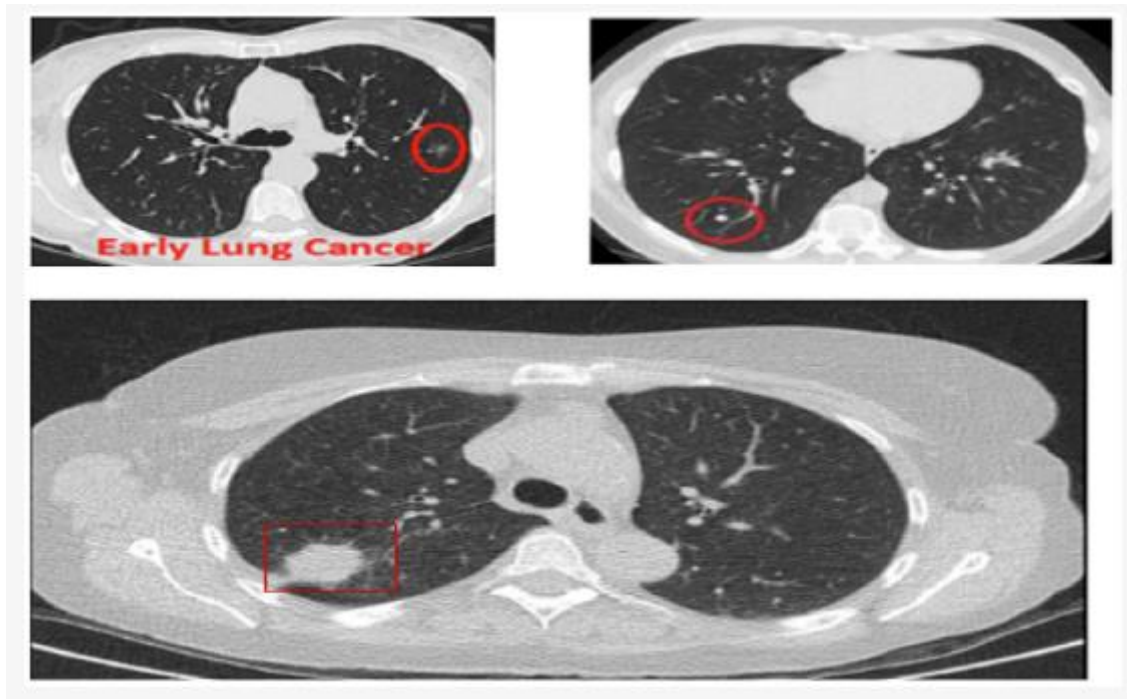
Lung CT scan showing a mass indicative of cancer [21]. Copyright 2022 by the authors.
